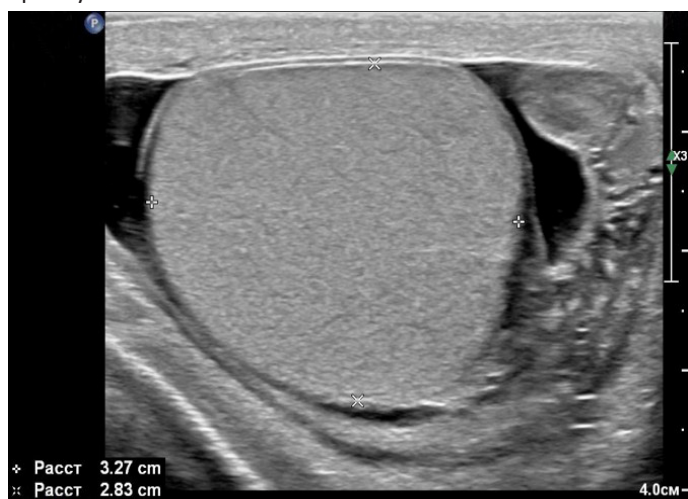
Ultrasound image of a moderate amount of simple fluid surrounding the testis outward along the extraperitoneal field.
